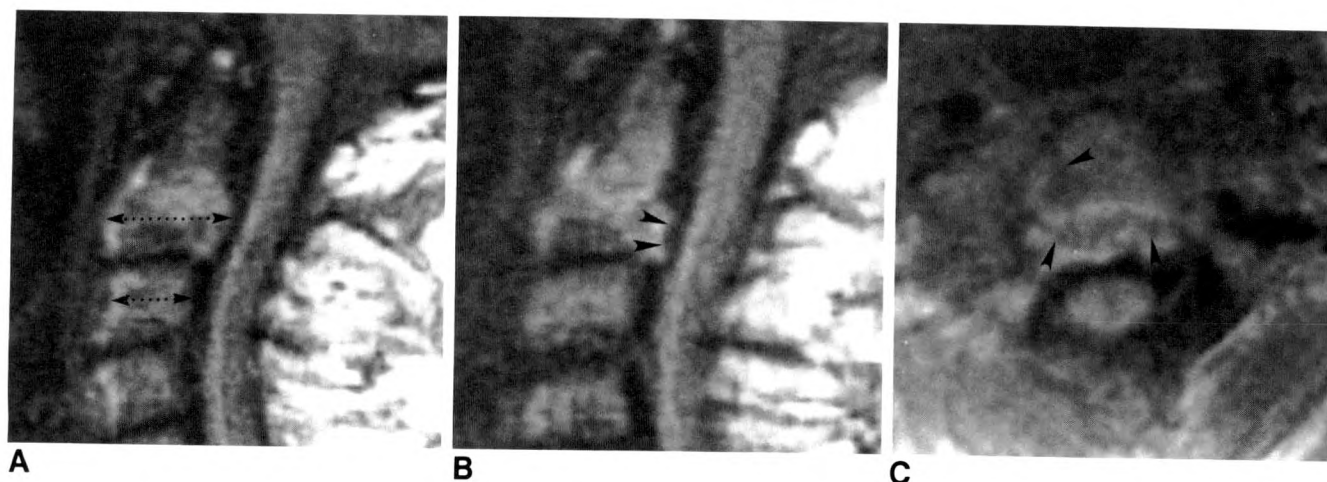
A, Midsagittal T1-weighted MR scan shows a fat C2. In midline, expansion of C2 is noted to be both anterior and posterior. B, Right parasagittal MR scan—right portion of fragment is displaced more posteriorly (arrowheads). No significant cord compression is identified, although ventral subarachnoid space is compromised. C, Axial T1-weighted MR scan shows components of fracture (arrowheads).
